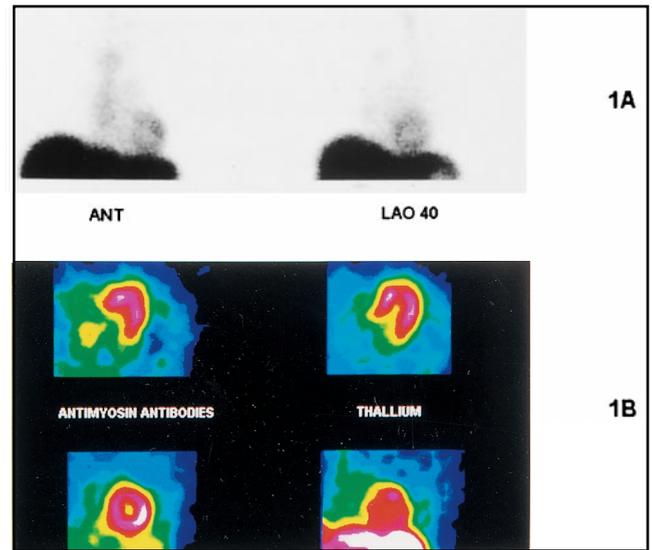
Scintigraphic pattern of diffuse myocarditis. The AMA planar images (A, HLR 2.1) and ^{111}In -AMA/ ^{201}Tl SPECT data (B, corresponding ^{111}In -AMA and ^{201}Tl slices) show diffuse AMA uptake throughout the whole LV myocardium, as well as normal ^{201}Tl uptake. ANT = anterior; LAO = left anterior oblique.
